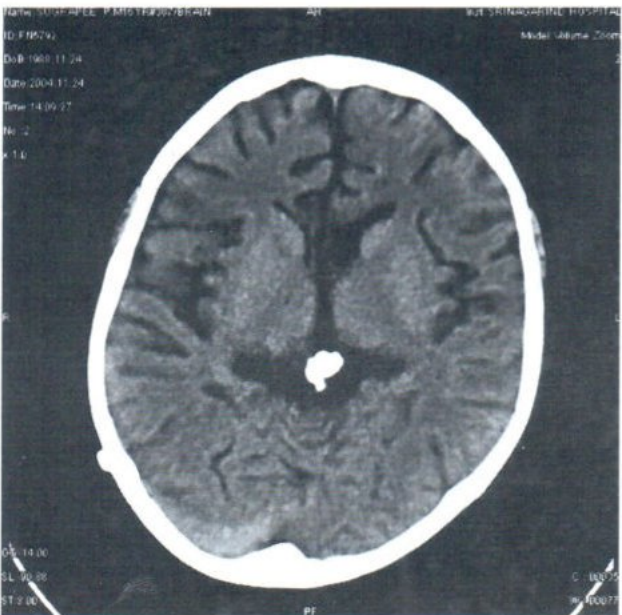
Computed tomography brain scans revealed no evidence of tumor left in ventricles after treatment (tumor dose 2850 cGy in 9 weeks), with improvement of hydrocephalus in comparison with the CT taken 5 weeks before, after having a tumor dose of 575cGy in 4 weeks in Fig.1I and Fig.1K above.
